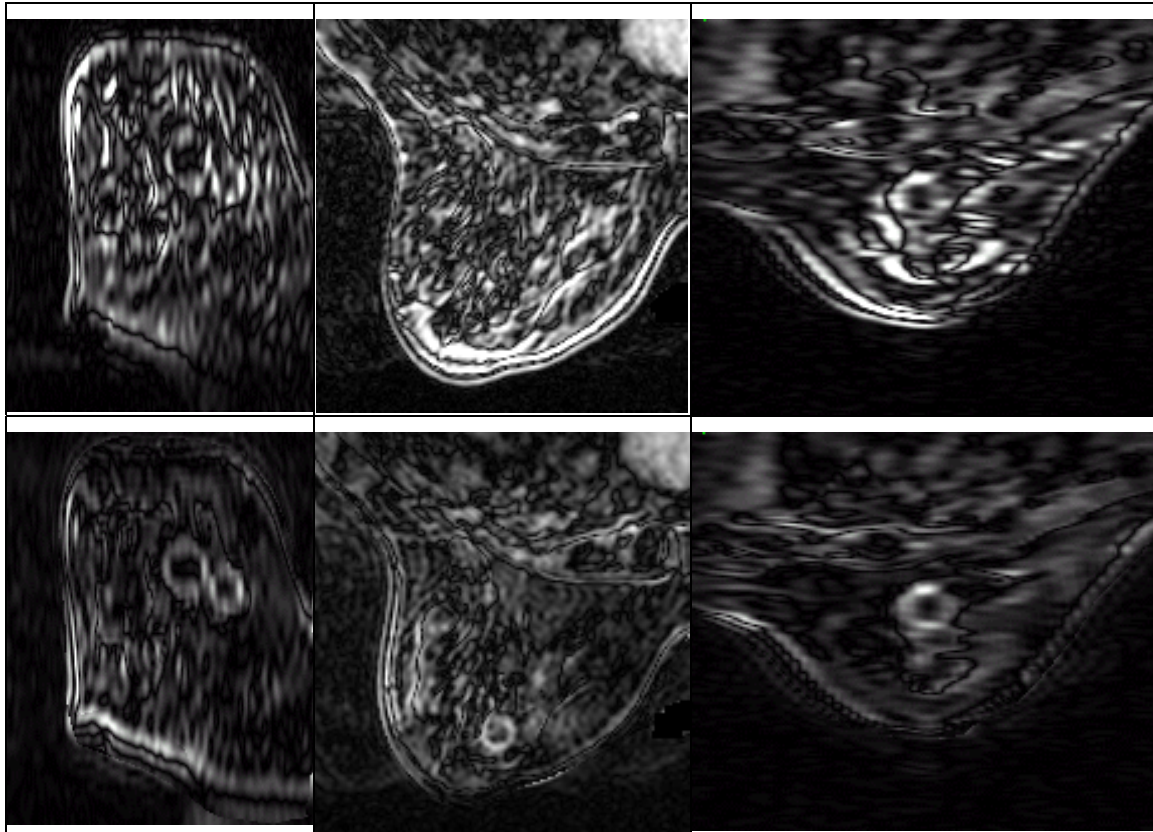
MRI differential images top row from left to right: coronal, transaxial, and sagittal views after rigid registration. Bottom row from left to right: coronal, transaxial, and sagittal views after FEM registration. Lesions which are difficult to identify after rigid registration are clearly visible after FEM registration.
